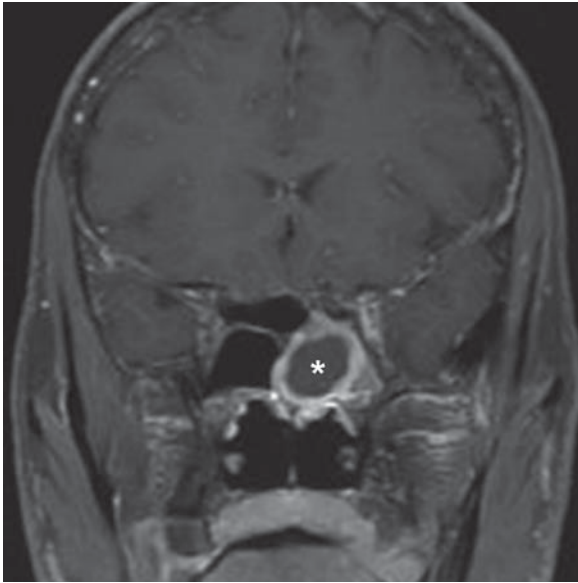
Mucosal enhancement around a polyp. Coronal contrast-enhanced T1-weighted MR image shows a low-signal polyp (*asterisk*) surrounded by a rim of enhancement. This rim of surrounding thickened mucosa should not be mistaken for the rim enhancement of a necrotic tumor
